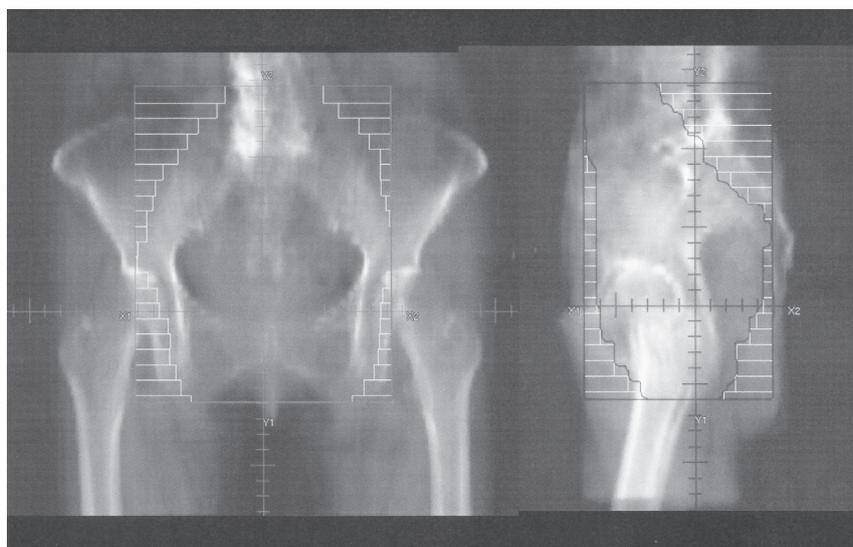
Digitally reconstructed radiographic image of the whole pelvic region as the irradiation field in large field.
